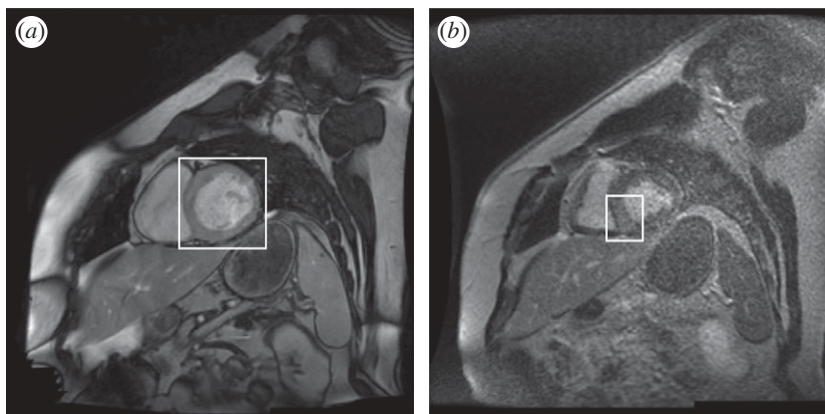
(a) Short-axis MRI of heart, indicating the left ventricle (LV); (b) Gd MRI of heart, indicating the brighter necrotic area in the septal region of the myocardium.
